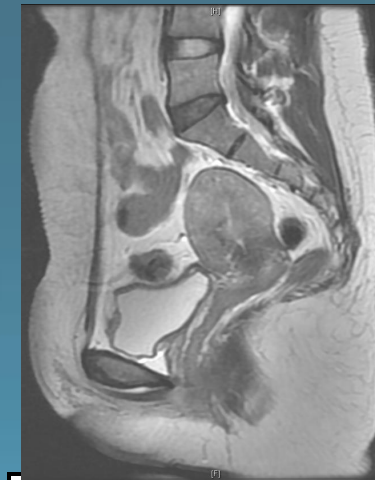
MRI Pelvis 4 months post hysteroscopic resection
